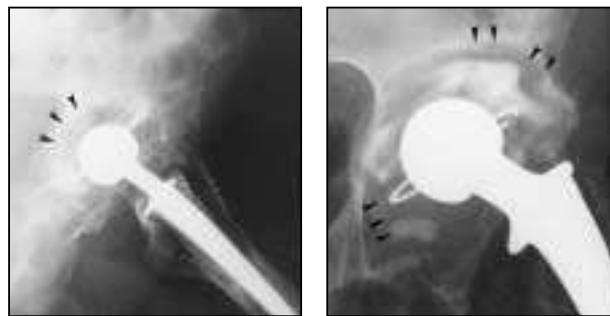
Left, Linear osteolysis about a cemented socket, which has collapsed into the circumferential osteolytic cavity, giving the appearance of a thin linear region of radiolucency (large arrows). Also note the expansile osteolysis in femoral zones 8 and 14 (small arrows). The radiographic also demonstrates definite loosening of the femoral component as evidenced by stem-cement debonding (open arrow). Right, Focal osteolysis around a cemented cup, resulting in expansile lesion and subsequent catastrophic failure of the implant (arrows).
